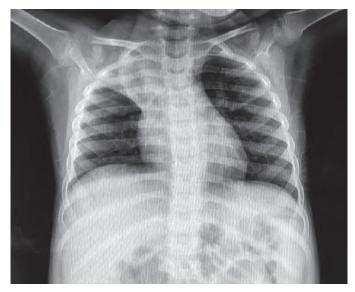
Chest radiograph: Right upper zone consolidation
